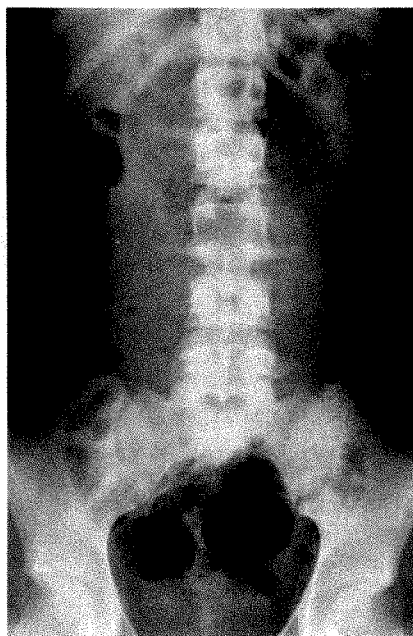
Plain abdominal roentgenogram demonstrating a dilated loop of small bowel in the epigastrium. Chance fracture of L3 is seen.
